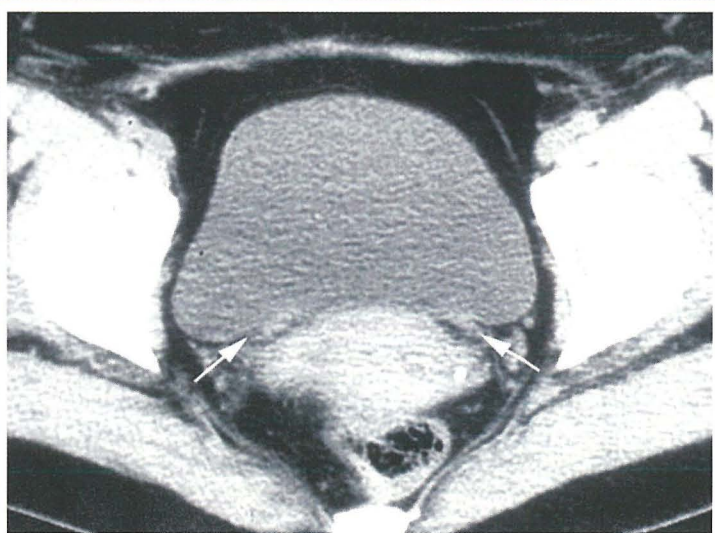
Normal ureterovesical junctions. Axial CT scan shows bilateral hyperattenuating areas of focal thickening of the posterior bladder wall (arrows), an appearance that represents normal ureterovesical junctions.
